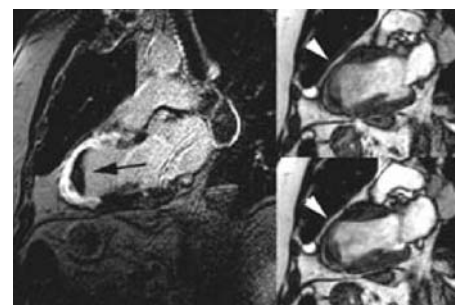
2D DE-MRI in a patient with chronic ischemic disease of the left anterior descending artery distribution. A two-chamber long axis image (left) reveals thinned tissue with transmural hyperenhancement involving the majority of the anterior wall, and entire apex, indicating a chronic transmural myocardial infarction. The left ventricular cavity is dilated and there is apical thrombus (black arrow). Cine images (right) at end-diastole (upper) and end-systole (lower) demonstrate akinesis of the anterior wall and apex (arrowhead).
